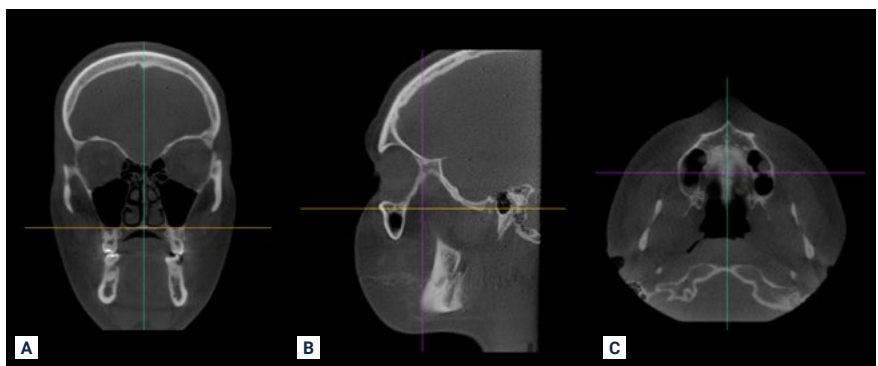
Spatial reorientation of the CBCT multiplanar reconstructions. (A) - Coronal view - Vertical reference line positioned parallel to the median sagittal plane. (B) - Sagittal view: Frankfurt Horizontal Plane as reference. (C) - Axial view - Vertical reference line passing through the anterior and posterior nasal spines.
